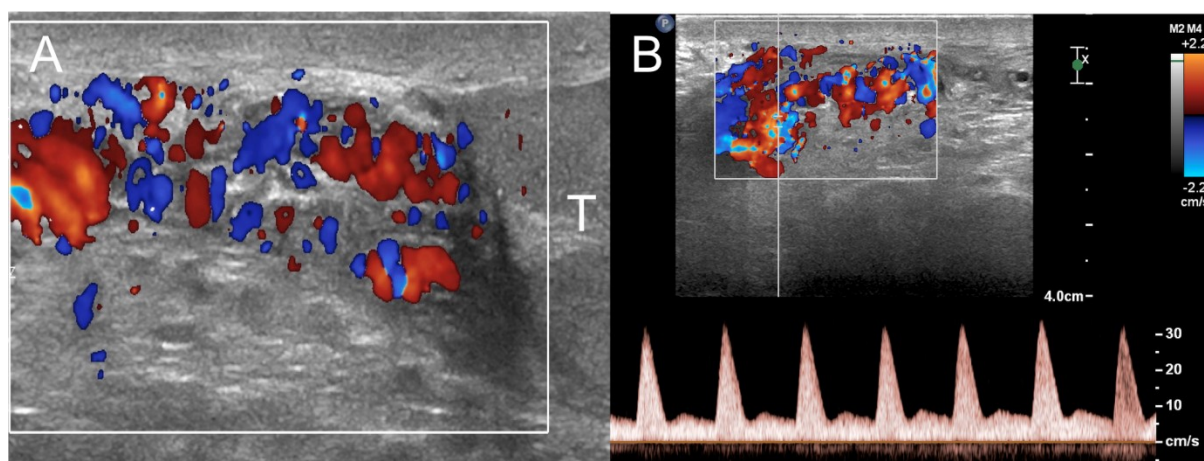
Scrotal arteriovenous malformation mimicking varicocele. (A) Colour Doppler US shows dilated vessels above the testis, resembling supratesticular varicocele (B) Spectral Doppler interrogation reveals high velocity arterial flows. (T=testis).
